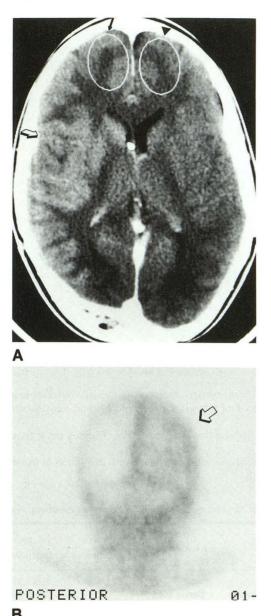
A, Contrast-enhanced CT scan after an osmotic bloodbrain barrier disruption in the right internal carotid artery on patient 12. This was a grade 2 (good) disruption in the right middle cerebral artery territory (open arrow). The circles show the territories for region of interest calculation by the left (arrowhead) and right (arrow) anterior cerebral artery distributions.
